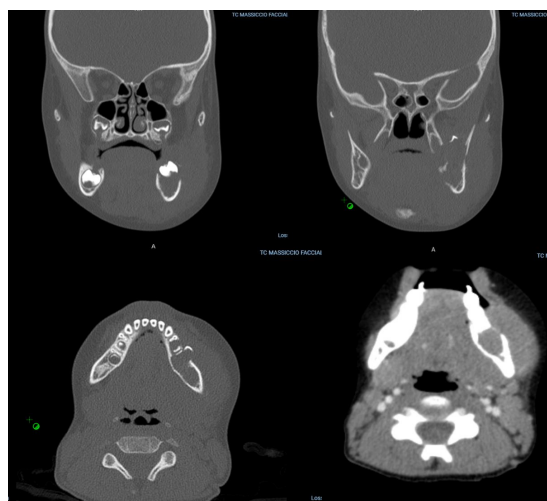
CT scan with contrast showing osteolytic lesion.
